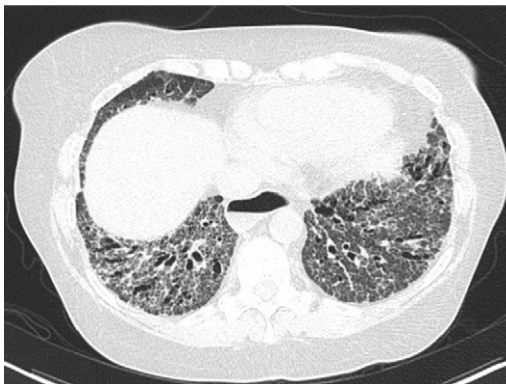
HRCT of a patient with SSc demonstrating moderate bibasilar predominant ground-glass opacifications, reticulation, and traction bronchiectasis suggestive of fibrotic NSIP. Note the markedly dilated, fluid-filled esophagus characteristic of SSc.
